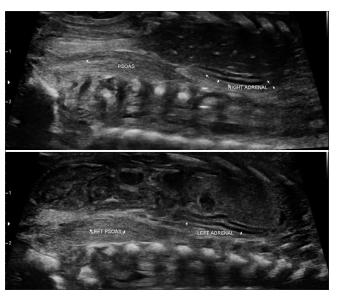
Ultrasound of the abortus confirming agenesis of both kidneys with lying down adrenal sign.
